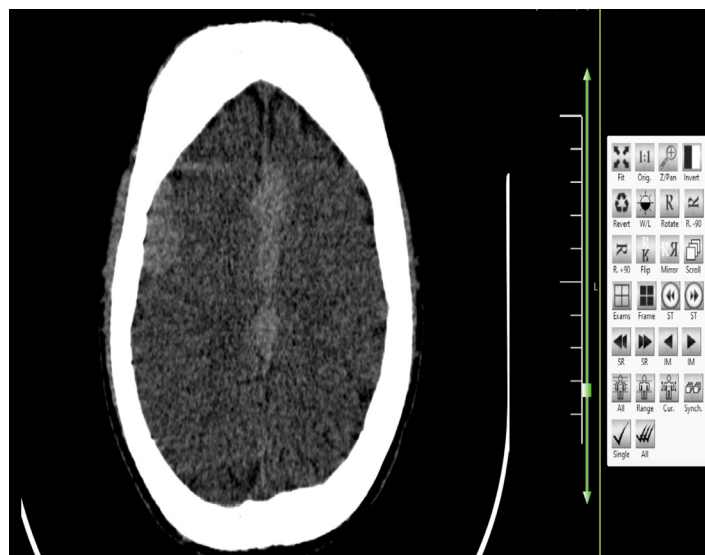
Non-contrast brain Computed Tomography (CT) scan
